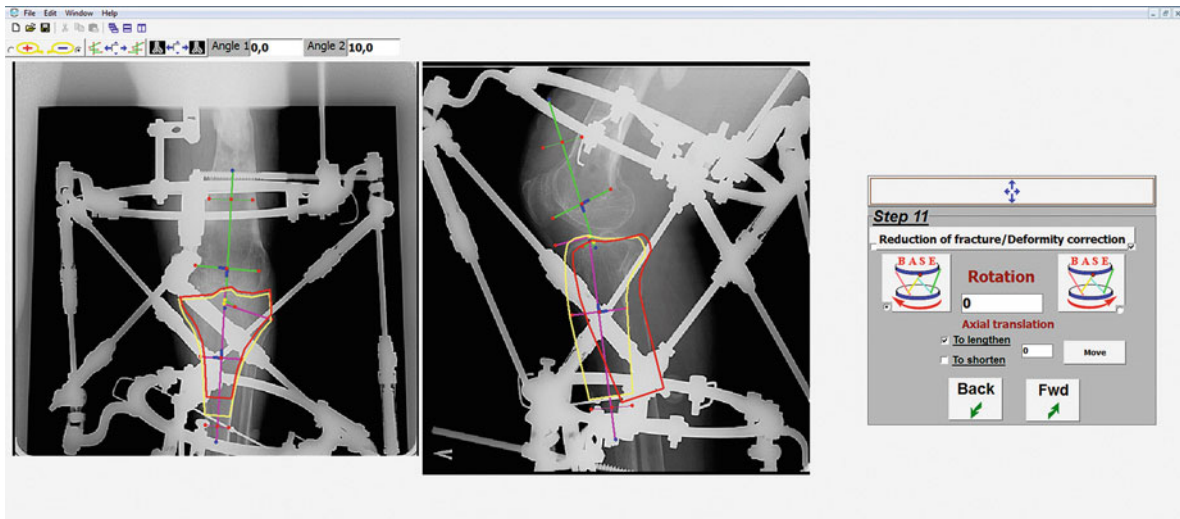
The Ortho-SUV software window at step 11: planning movement in the knee joint. The yellow bone contour indicates the initial tibial bone position. The red bone contour indicates the position of the tibia at each increment of 5° flexion increase
